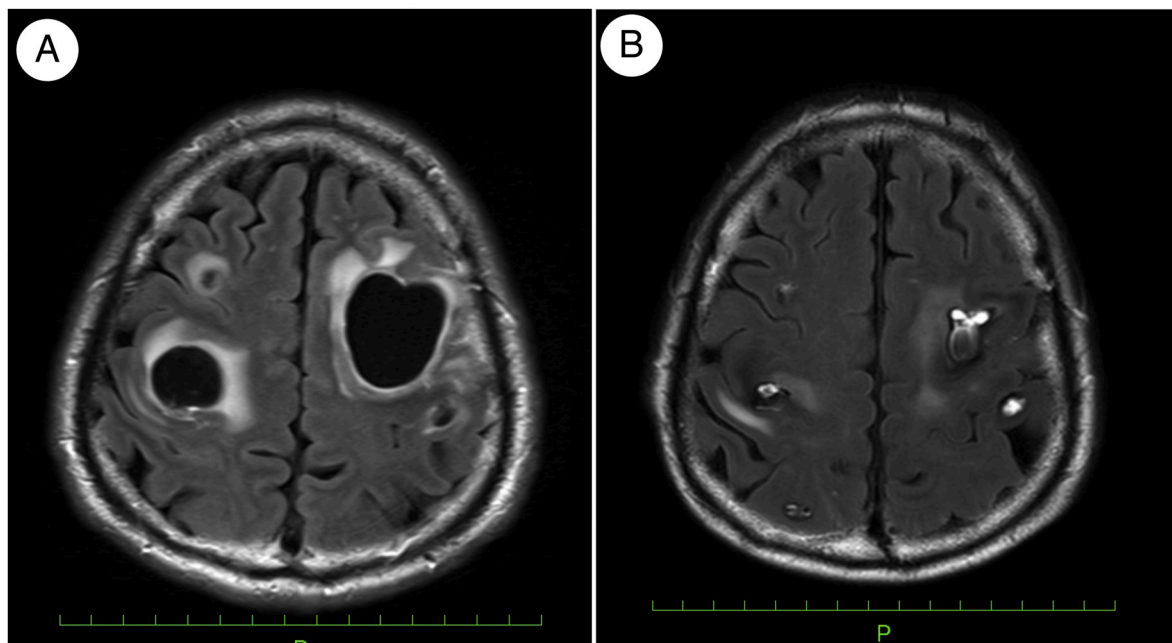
Brain MRI images on admission (A) and after the placement of Ommaya reservoirs (B). A: FLAIR imaging shows large cystic brain tumors and multiple small cystic nodules. B: After Ommaya reservoir placement, the giant cysts on both sides decreased in size.
